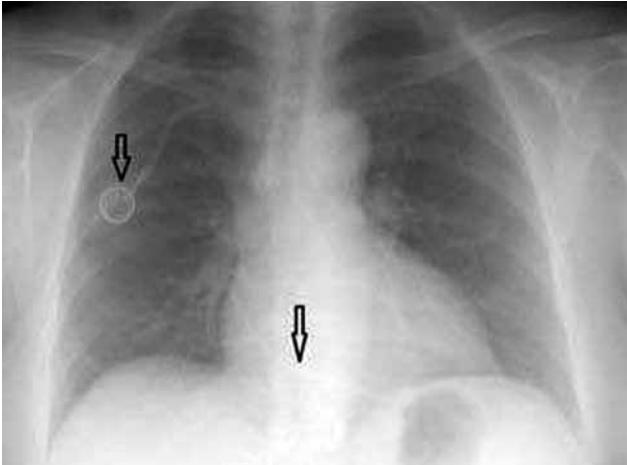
A chest X-ray view showing part of diaphragm and intracardiac fragment of fractured totally implantable venous access port with arrows.
